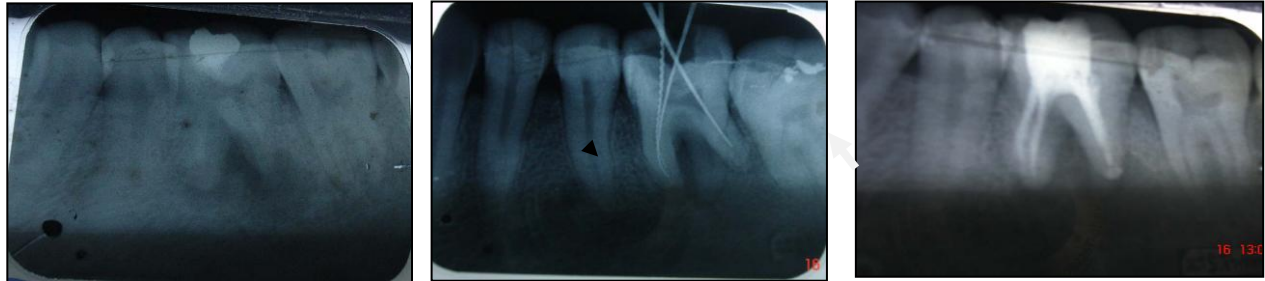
(A) Preoperative radiograph (b) Length determination radiograph, where the RE is visualized (Demarked).
